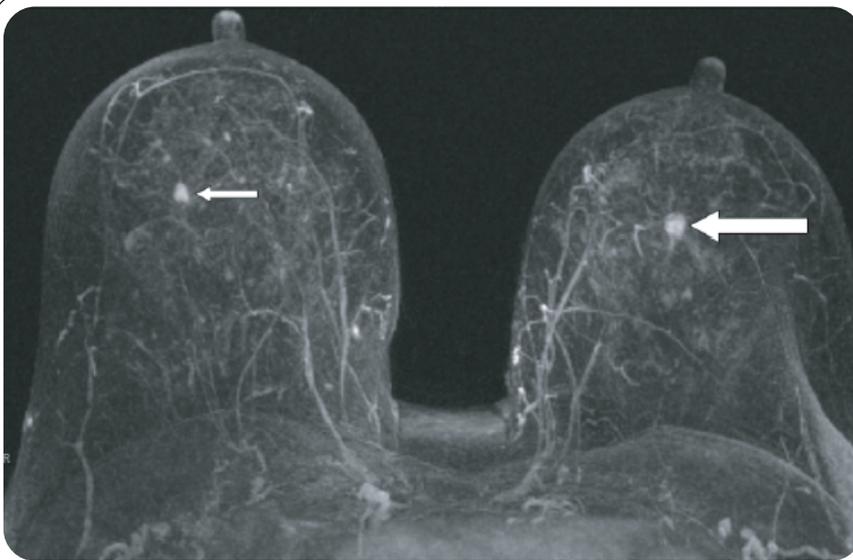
Breast MRI demonstrating the known biopsy-proven cancer (large arrow) and contralateral breast cancer (small arrow) that was not detected on mammography.
